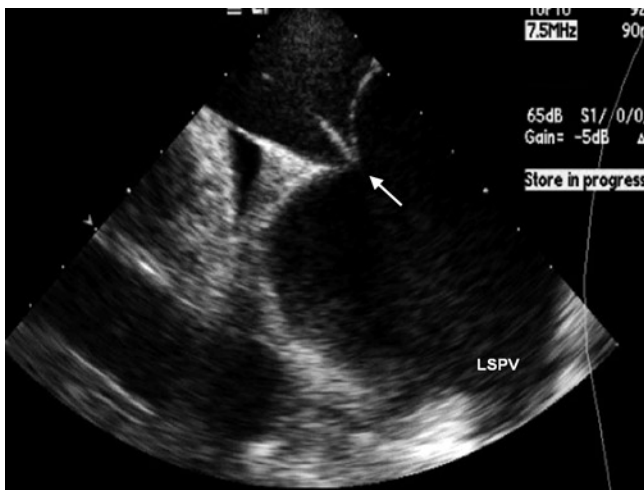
An intracardiac echocardiography image of a transseptal system (sheath and needle) positioned at the fossa ovalis during a transseptal puncture. The image is obtained with the intracardiac echocardiography imaging probe placed in the right atrium. Tenting of the interatrial septum is noted. In this image, the transseptal apparatus is aligned with the left superior pulmonary vein (LSPV) in the imaging view. This provides an optimal trajectory to puncture the septum during atrial fibrillation ablation procedures
